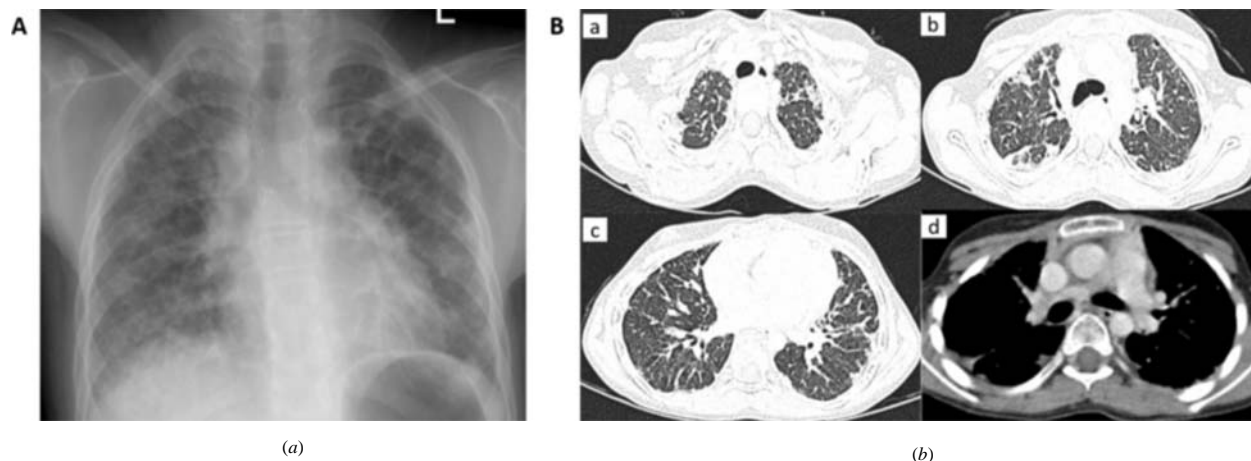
a) Chest X-ray image of the index case showing multiple reticulo-nodular shadows in all lung fields. High resolution computed tomography chest images of the index case showing septal thickening with fibrotic changes in all lobes (a, b and c) with normal mediastinal structures and pulmonary artery caliber (d).
